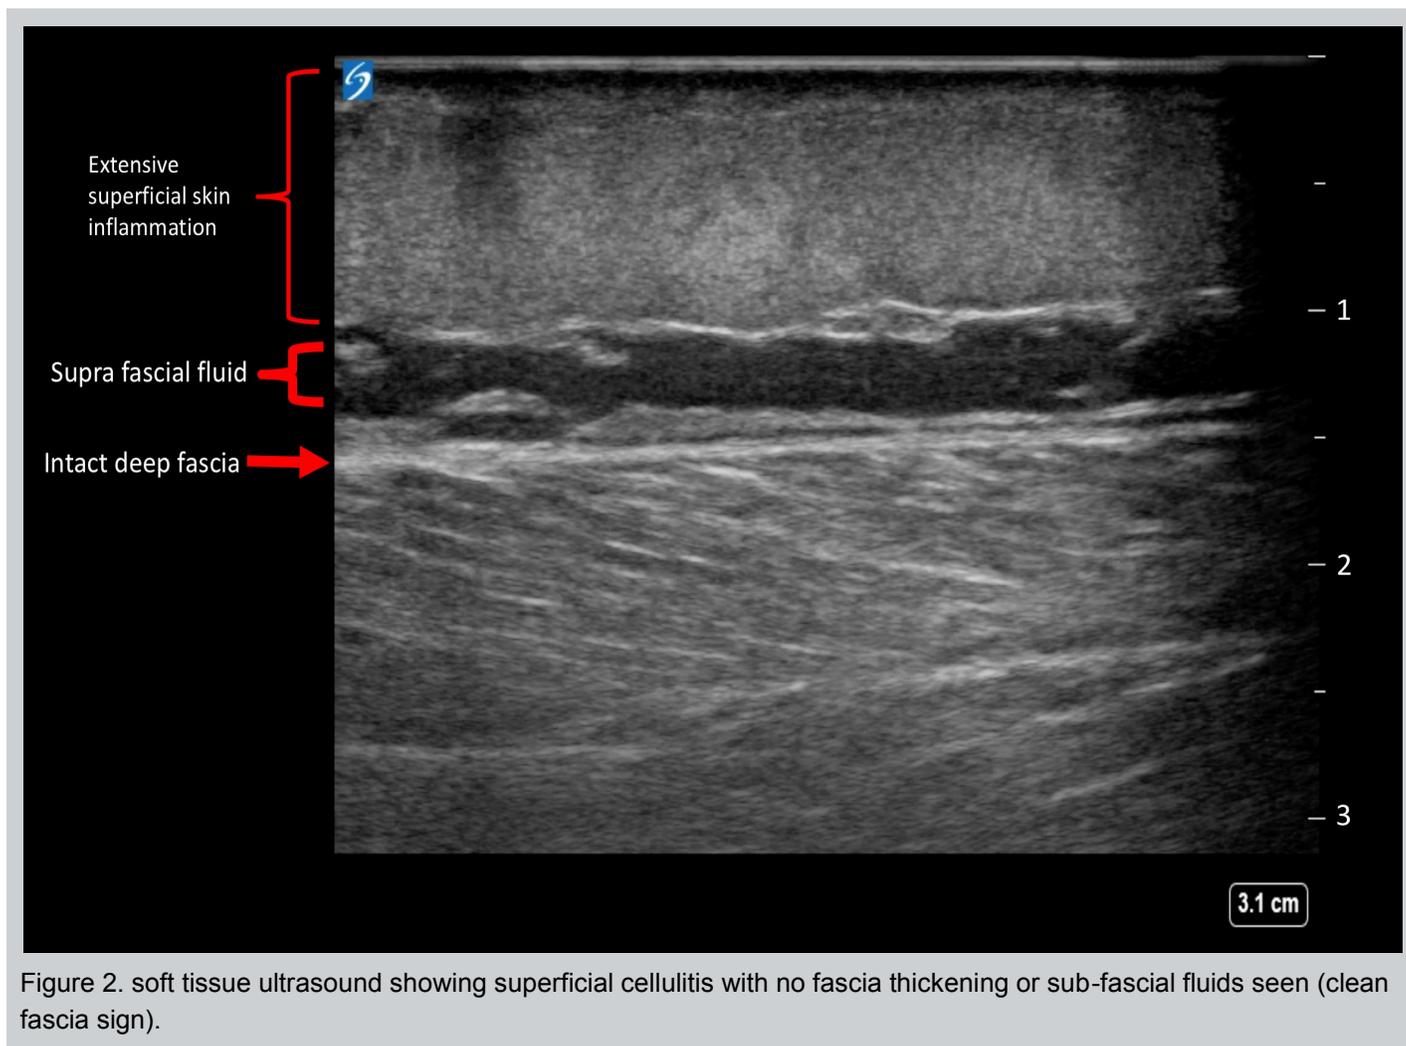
soft tissue ultrasound showing superficial cellulitis with no fascia thickening or sub-fascial fluids seen (clean fascia sign).
